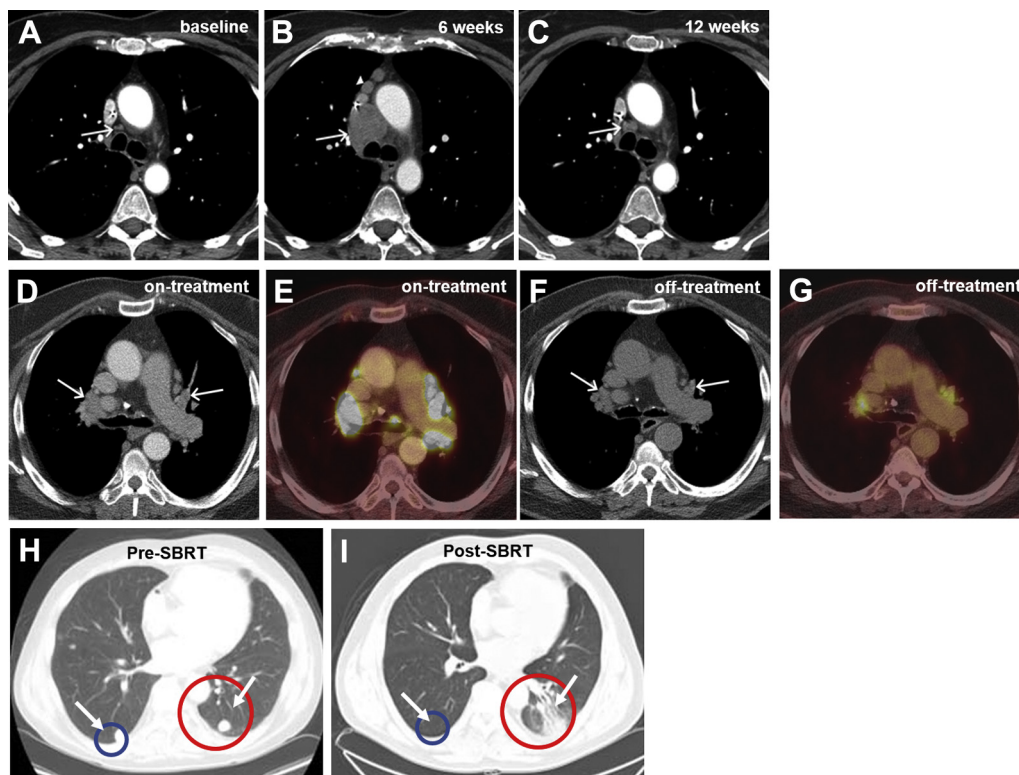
Imaging changes in response to immunotherapy. (A-C) Axial contrast-enhanced computed tomography (CT) scan demonstrating pseudoprogression in a patient treated with immunotherapy for advanced lung cancer. Marked interval enlargement of right paratracheal lymph node (arrow) and development of new prevascular mediastinal adenopathy (arrow head) 6 weeks after treatment compared with baseline (A-B). Follow-up CT scan 6 weeks later (12 weeks; C) demonstrates interval decrease in right paratracheal node and disappearance of other nodes. (D-G) CT and fused [^{18}F]FDG positron emission tomography/CT scan of metastatic melanoma patient on-treatment with immunotherapy with development of new FDG-avid mediastinal/hilar adenopathy (arrows, D-E). Discontinuation of therapy because of suspected immune-related adverse event. Repeat imaging 6 weeks after treatment termination (F-G) demonstrated substantial decrease in size and avidity of nodes. Biopsy test results demonstrated sarcoid-like reaction and no evidence of malignancy. (H-I) Pre- and posttreatment nonenhanced axial CT images in patient with metastatic renal cell carcinoma treated with stereotactic body radiation therapy to posterior left lung lesion, followed by high-dose interleukin-2 with development of fibrotic changes (red) in site of stereotactic body radiation therapy and resolution of nonirradiated nodule (blue) in contralateral lung. Treatment-related radiographic changes complicate assessment of local control.^{26,96} Images adapted with permission for reuse ©2018 American Cancer Society and ©2012 American Association for the Advancement of Science.
